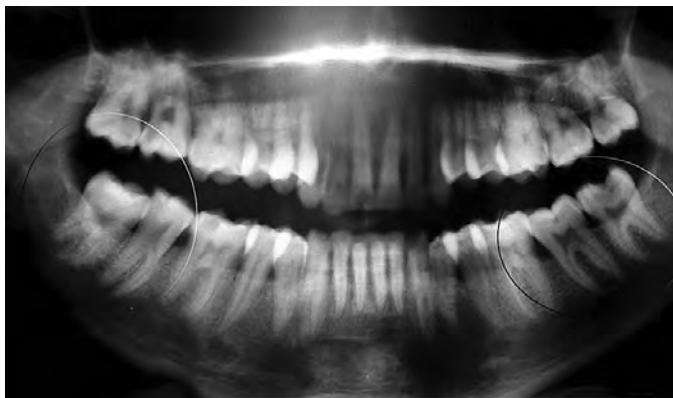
A panoramic radiograph showing mandibular right third molar having extra root radix paramolaris and a mandibular left third molar showing two separate roots. Case is a 21 year old male.
